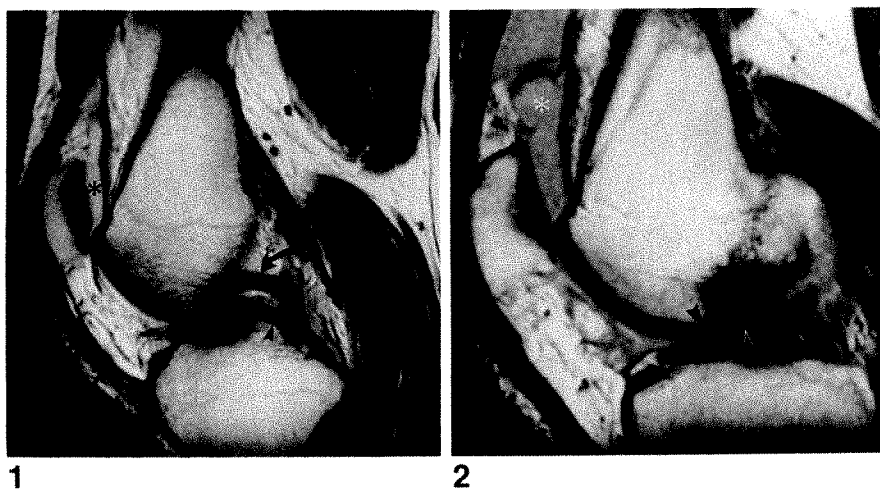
37-year-old man who injured his left knee at work 1 week before imaging studies. Bucket-handle tear of medial meniscus was proved by arthroscopy. SE 2000/25 sagittal MR image shows displaced fragment of torn medial meniscus (arrowheads) just anterior to posterior cruciate ligament (curved arrow). Asterisk = joint effusion.
